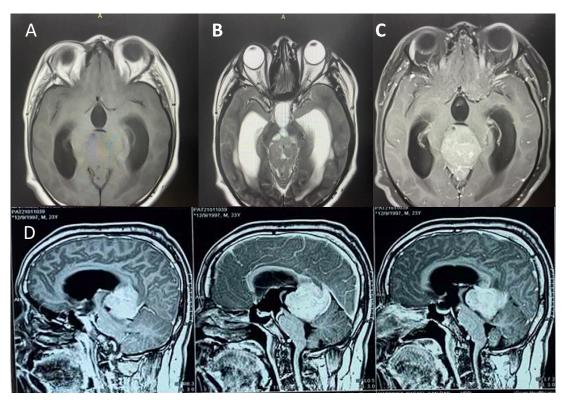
Pre-operative Cranial MRI with contrast: A. T1 axial, B. T2 axial, C. T1 with contrast, axial D. with sagittal view
